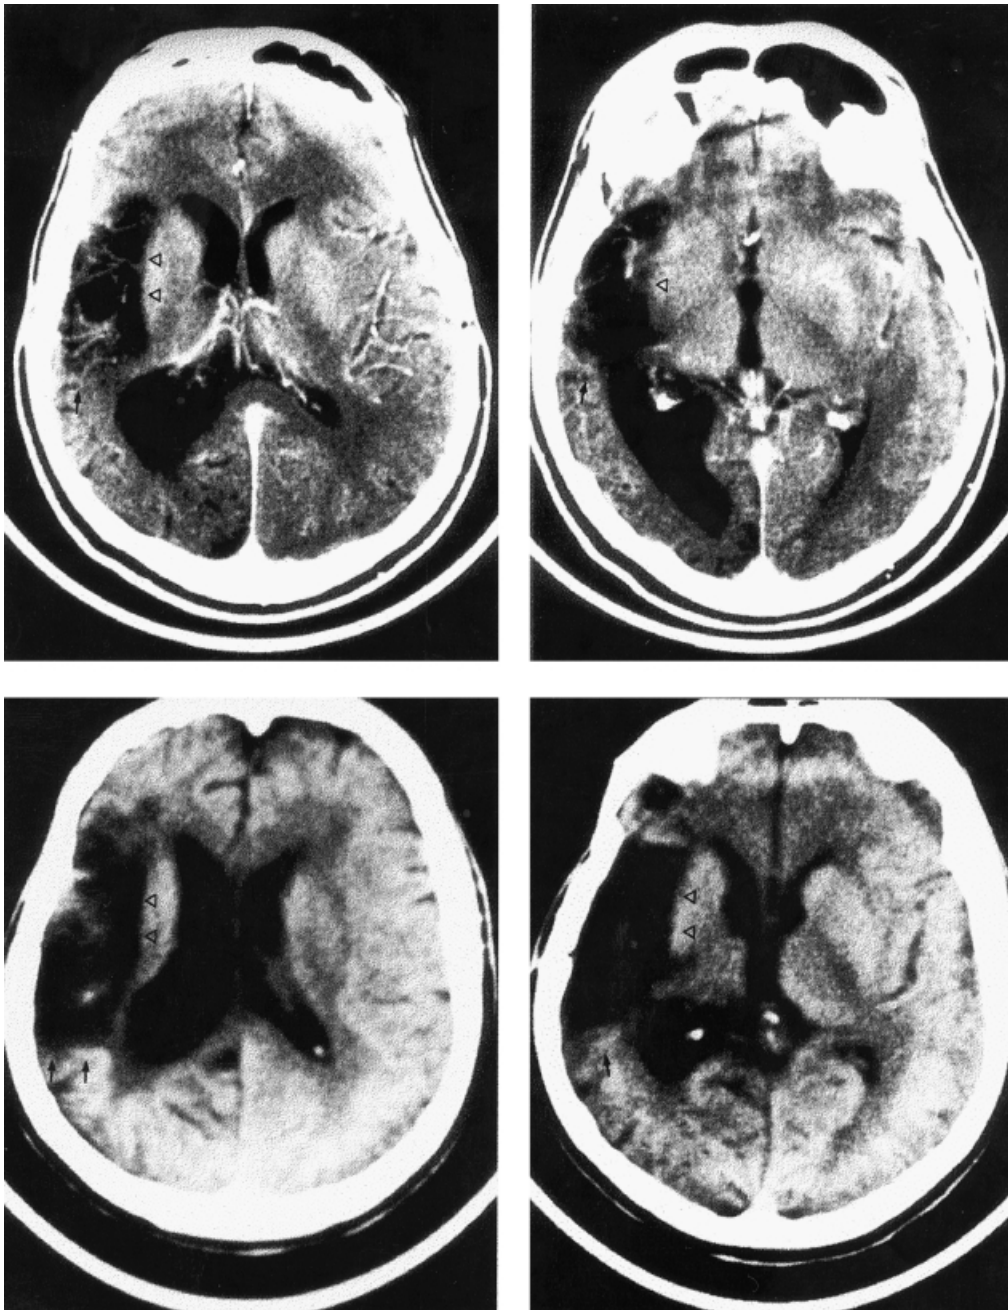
Axial CT scan images of the brain of two music agnostic patients, BBS19 or R.C. (top images, without contrast injection) and RBS16 or N.R. (bottom images, with contrast injection): MCA infarct involving the insular cortex (open arrowheads) and the temporal lobe (arrow) including Heschl's gyrus. The right side of the brain is on the left of the photograph.
